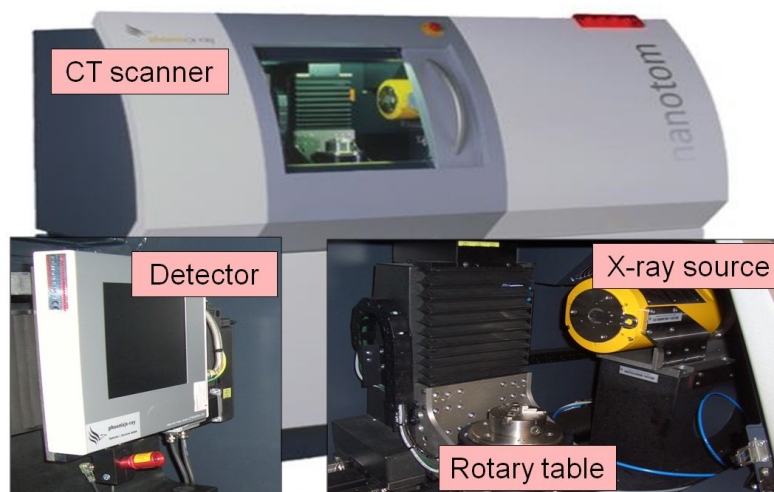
Industrial cone beam CT scanner [GE Phoenix|X-ray Nanotom].
